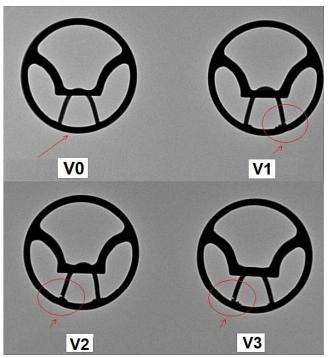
Overview of the placement and design of artificial defects in the BSCC implant (X-ray image).
